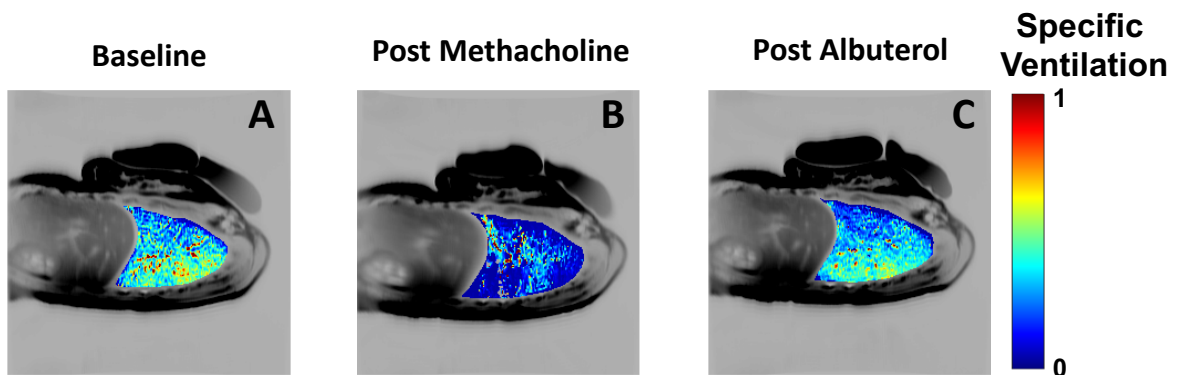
Figure A-3 – Specific ventilation measured in a mild asthmatic subject (female, age 23) at baseline (Panel A), following inhalation of methacholine (Panel B) and following inhalation of albuterol (Panel C). Note the significant changes in the distribution of specific ventilation following the induction of an asthma-like event using methacholine (Panel B), with large regions of the dependent lung showing little to no specific ventilation. Also note the subsequent return to baseline condition following bronchodilator administration (Panel C). As in Figure A-1, the specific ventilation maps have been overlaid into an anatomical MRI.
